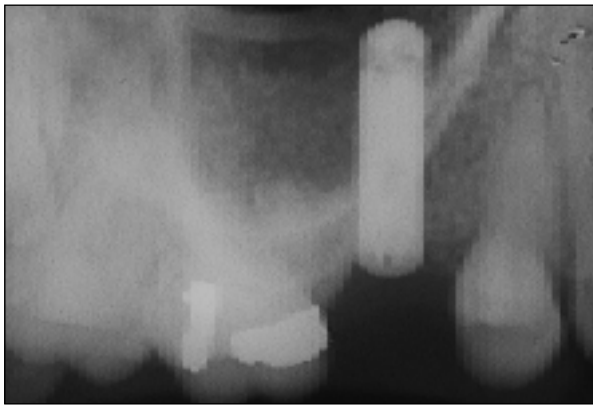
Postoperative radiograph showing cylindric HA-coated implant in the augmented sinus.
